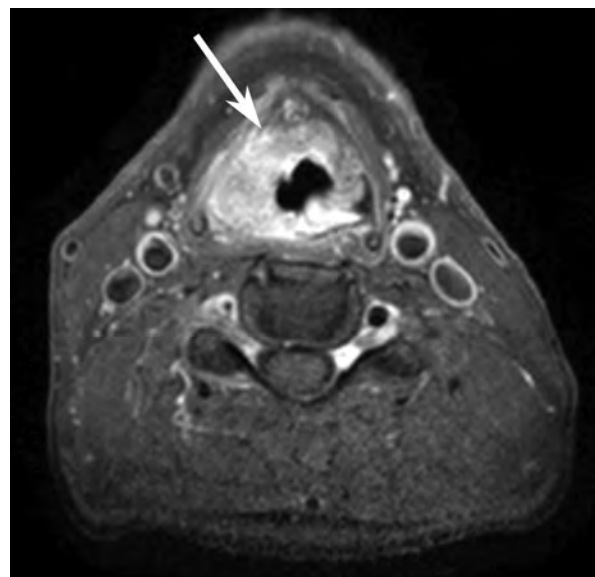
Transverse T1-weighted MR image with fat saturation. The infiltration of the pre-epiglottic space is indicated by the arrow.
